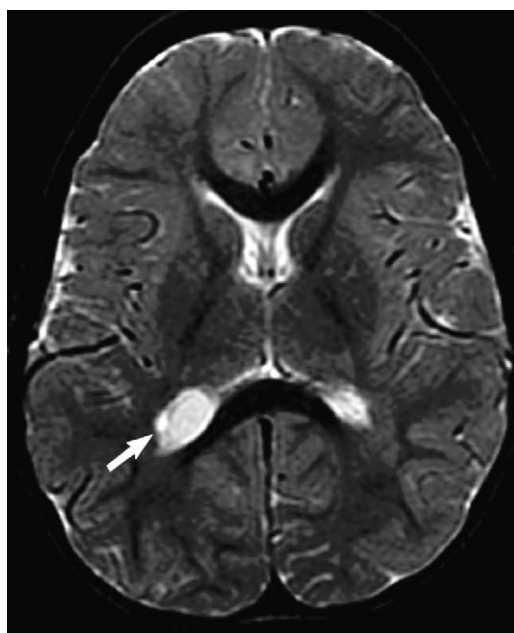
Choroid plexus cyst. Axial T2-weighted image demonstrates an oval, hyperintense, intraventricular cyst in the region of the glomus of the choroid plexus (arrow), characteristic of a choroid plexus cyst.
